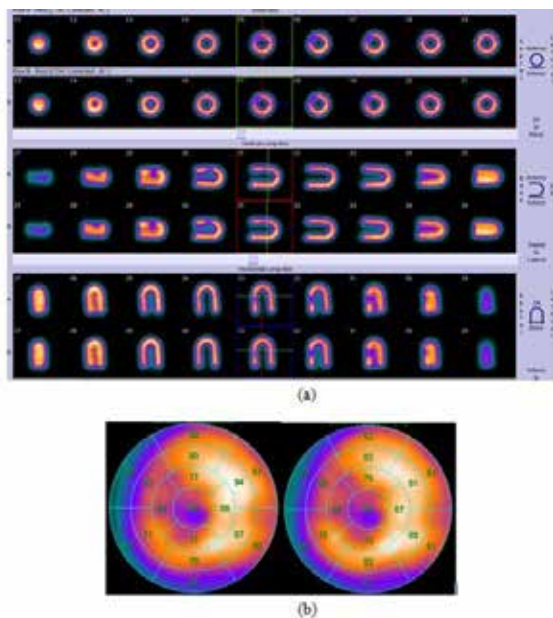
(a) The reconstructed SPECT images of a typical patient with ICD lead reoriented on typical short axis, vertical, and horizontal long axis with the ICD lead without MAR (top row) and with MAR (bottom row). (b) Bull's eye view of the attenuation-corrected SPECT images without (left) and with (right) MAR obtained using QPS software.
